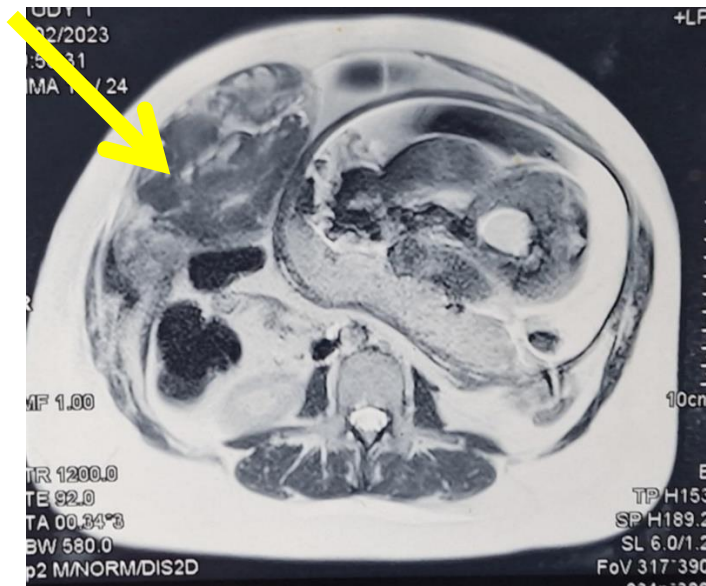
Magnetic resonance imaging showing a right rectus sheath hematoma during pregnancy
